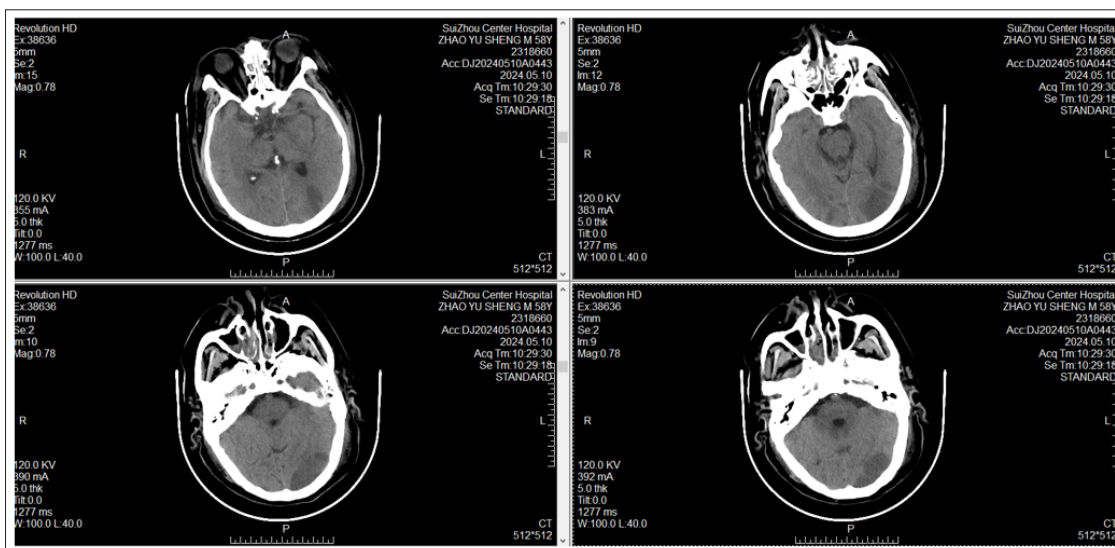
Craniocerebral CT examination on May 10: The left occipito-parietal lamellar low-density shadow is considered cerebral infarction.
